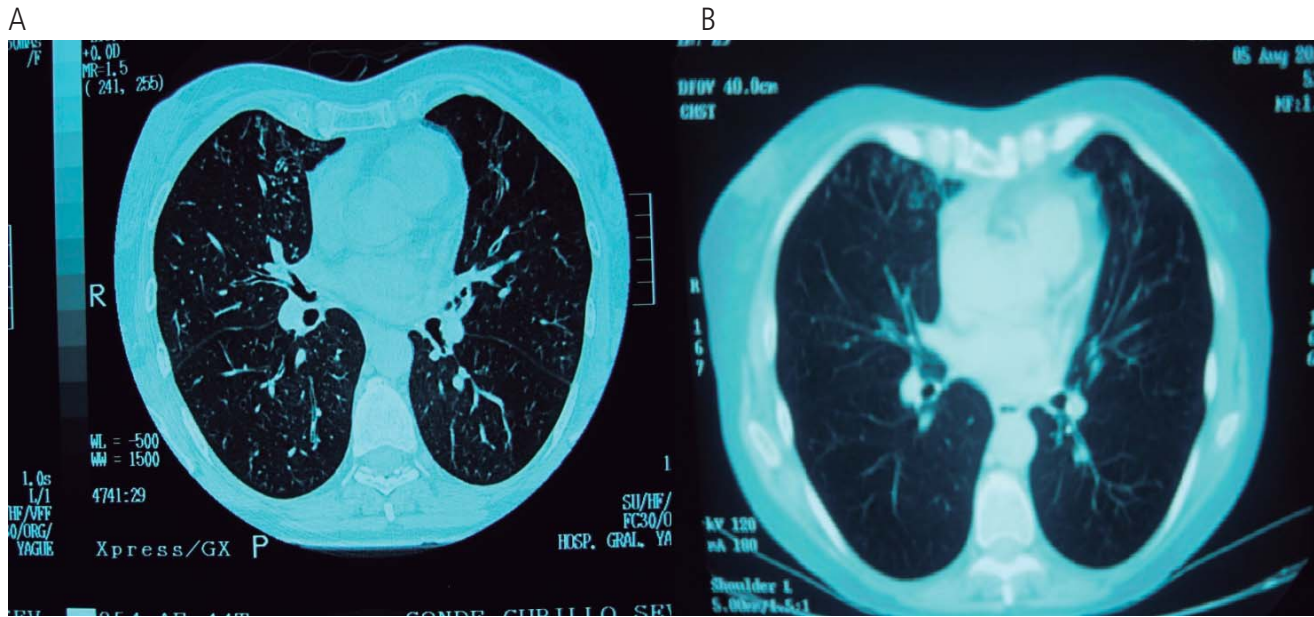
Computed tomography scan showing reduced bronchiectasis after 12 months of treatment with omalizumab. Left, Before therapy with omalizumab. Right, After therapy with omalizumab.
